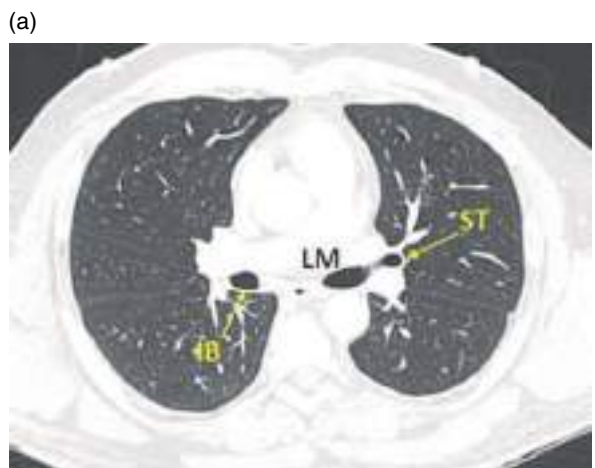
(a) Axial CT image (lung window). IB, intermediate bronchus; LM, left main bronchus; ST, superior trunk. (b) Axial CT image (mediastinal window). SPV, superior pulmonary vein; LPA, left pulmonary artery.
